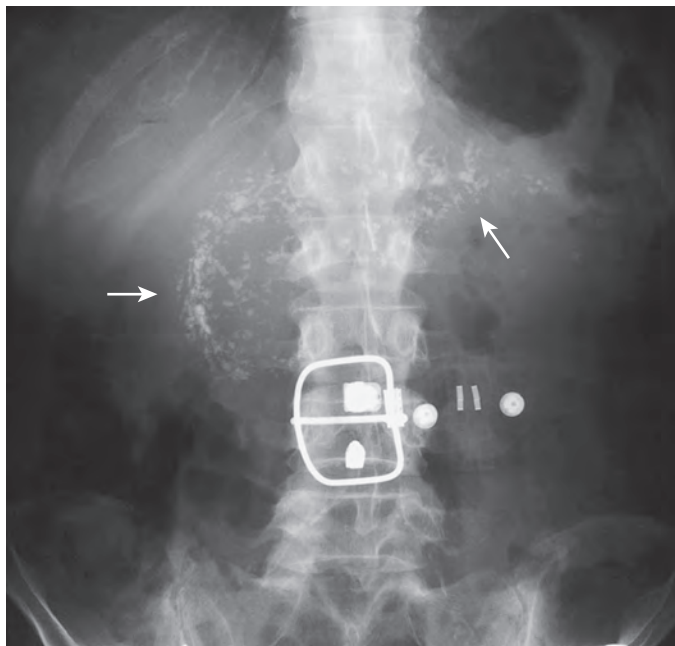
Pancreatic calcification. Supine abdominal radiograph shows multiple calcifications outlining the pancreas (arrows) caused by chronic pancreatitis. The pancreas normally is not visible on abdominal radiographs.
